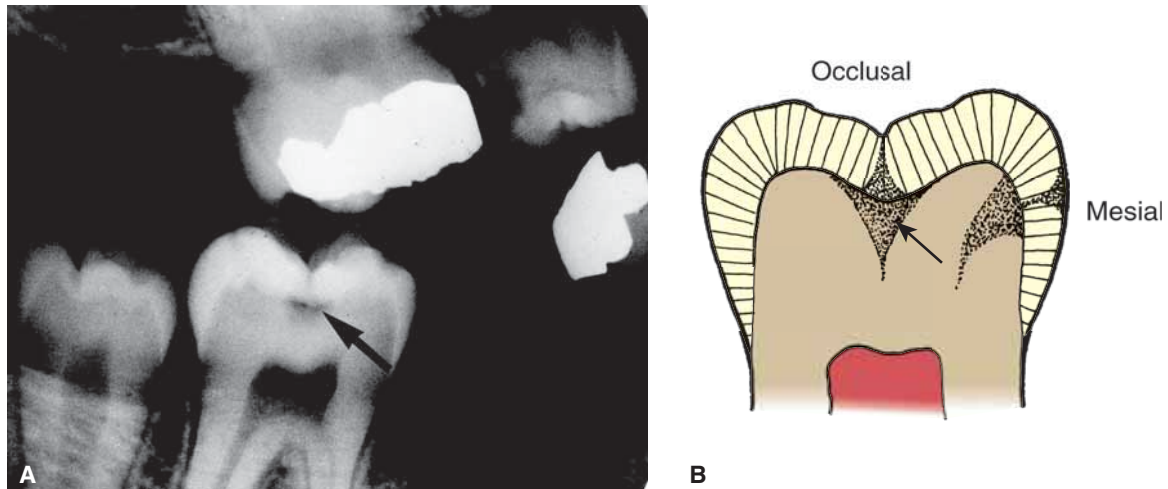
A. Radiograph of a class I lesion (arrow) on tooth No. 31. By the time the lesion appeared this deep on the radiograph, the caries had destroyed dentin to such a depth that a thermal-insulating base of some type of dental cement will possibly be needed to protect the pulp from thermal conductivity through the metal filling. This pit and fissure caries should have been detected earlier with a good clinical examination. (There is also a large distal class II lesion on tooth No. 4, which appears to be rotated [top right]). B. Spread pattern of class I decay: The occlusal lesion at the arrow (class I, pit and fissure) is small externally, widening toward the depth of the fissure as it approaches the DEJ. Once within dentin, the caries spreads out laterally, as well as progressing toward the pulp.
